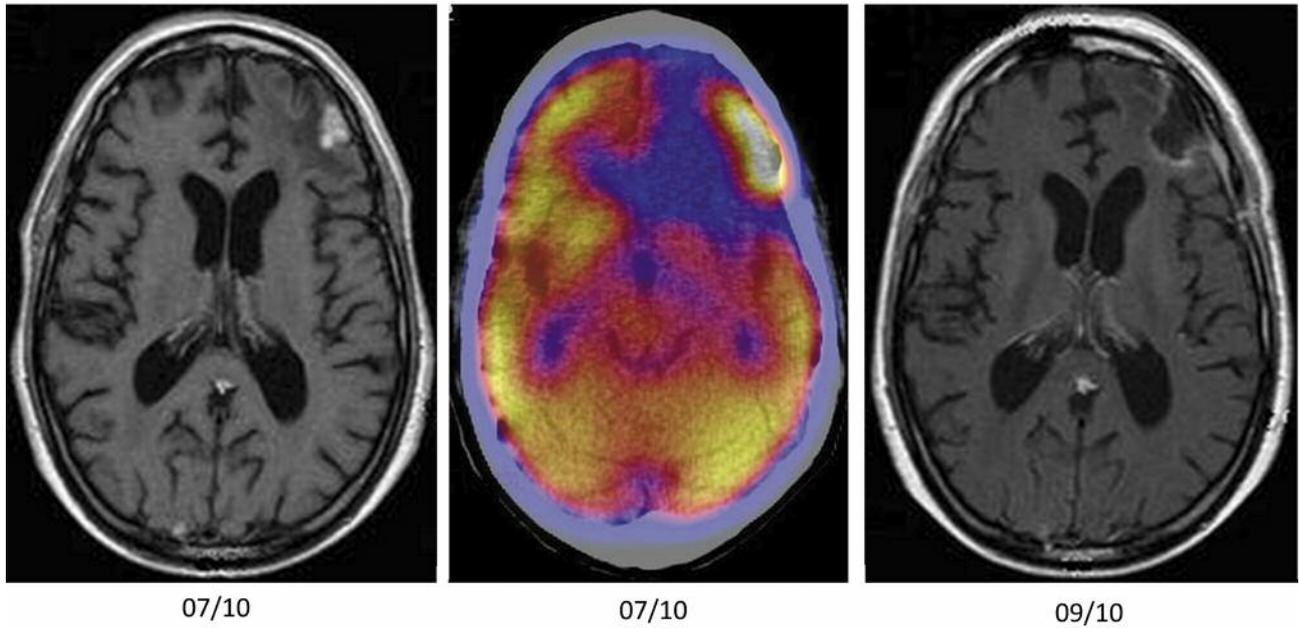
Patient NX left: Magnetic resonance imaging (MRI) scan shows contrast enhancement in the left parietal area, middle positron emission tomography scan fused with computerized tomography scan (PET/CT) is intensely positive and right MRI after excision biopsy which showed mainly radiation necrosis and only a small nest of viable tumor.
